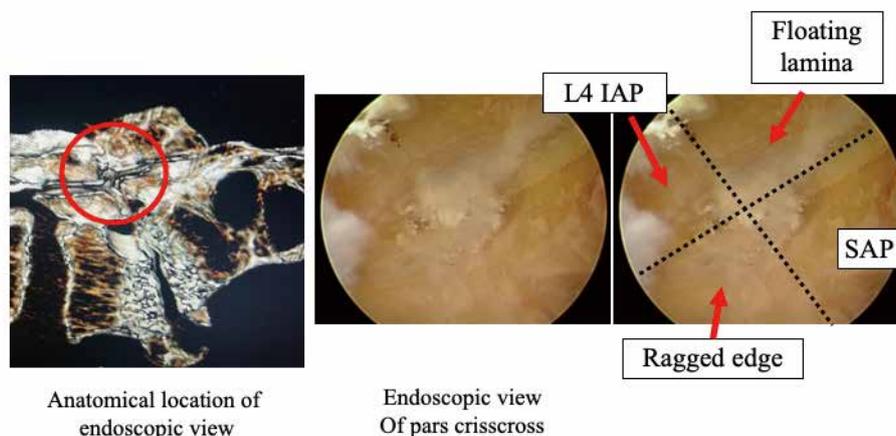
Endoscopic confirmation of the pars crisscross. When the soft tissues are cleaned up and the surface of SAP is shaved, the pars crisscross can be clearly visualized. The pars crisscross consists of the SAP of S1, the floating lamina, the inferior articular process of L4, and the pars ragged edge. The pars crisscross is shown on a sagittal computed tomography scan in the left panel and under an endoscopic view in the middle panel. The detail is explained in the right panel.
